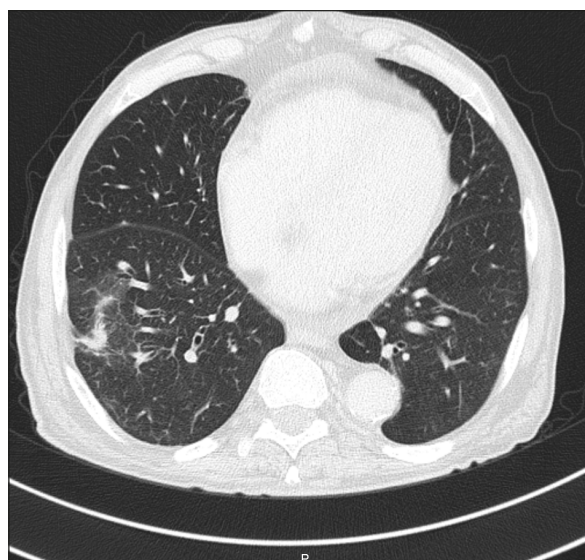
Chest computed tomography after four weeks from the end of albendazole treatment.
